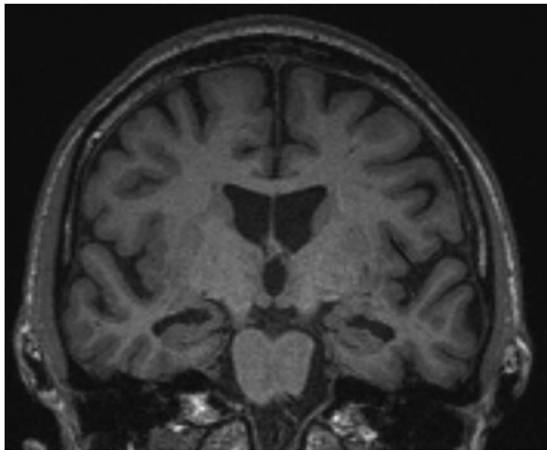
Coronal MRI of Case 2 showing moderate medial temporal cortical and hippocampal atrophy with relative sparing of other cortical regions, consistent with an amnesic neurodegenerative syndrome.
